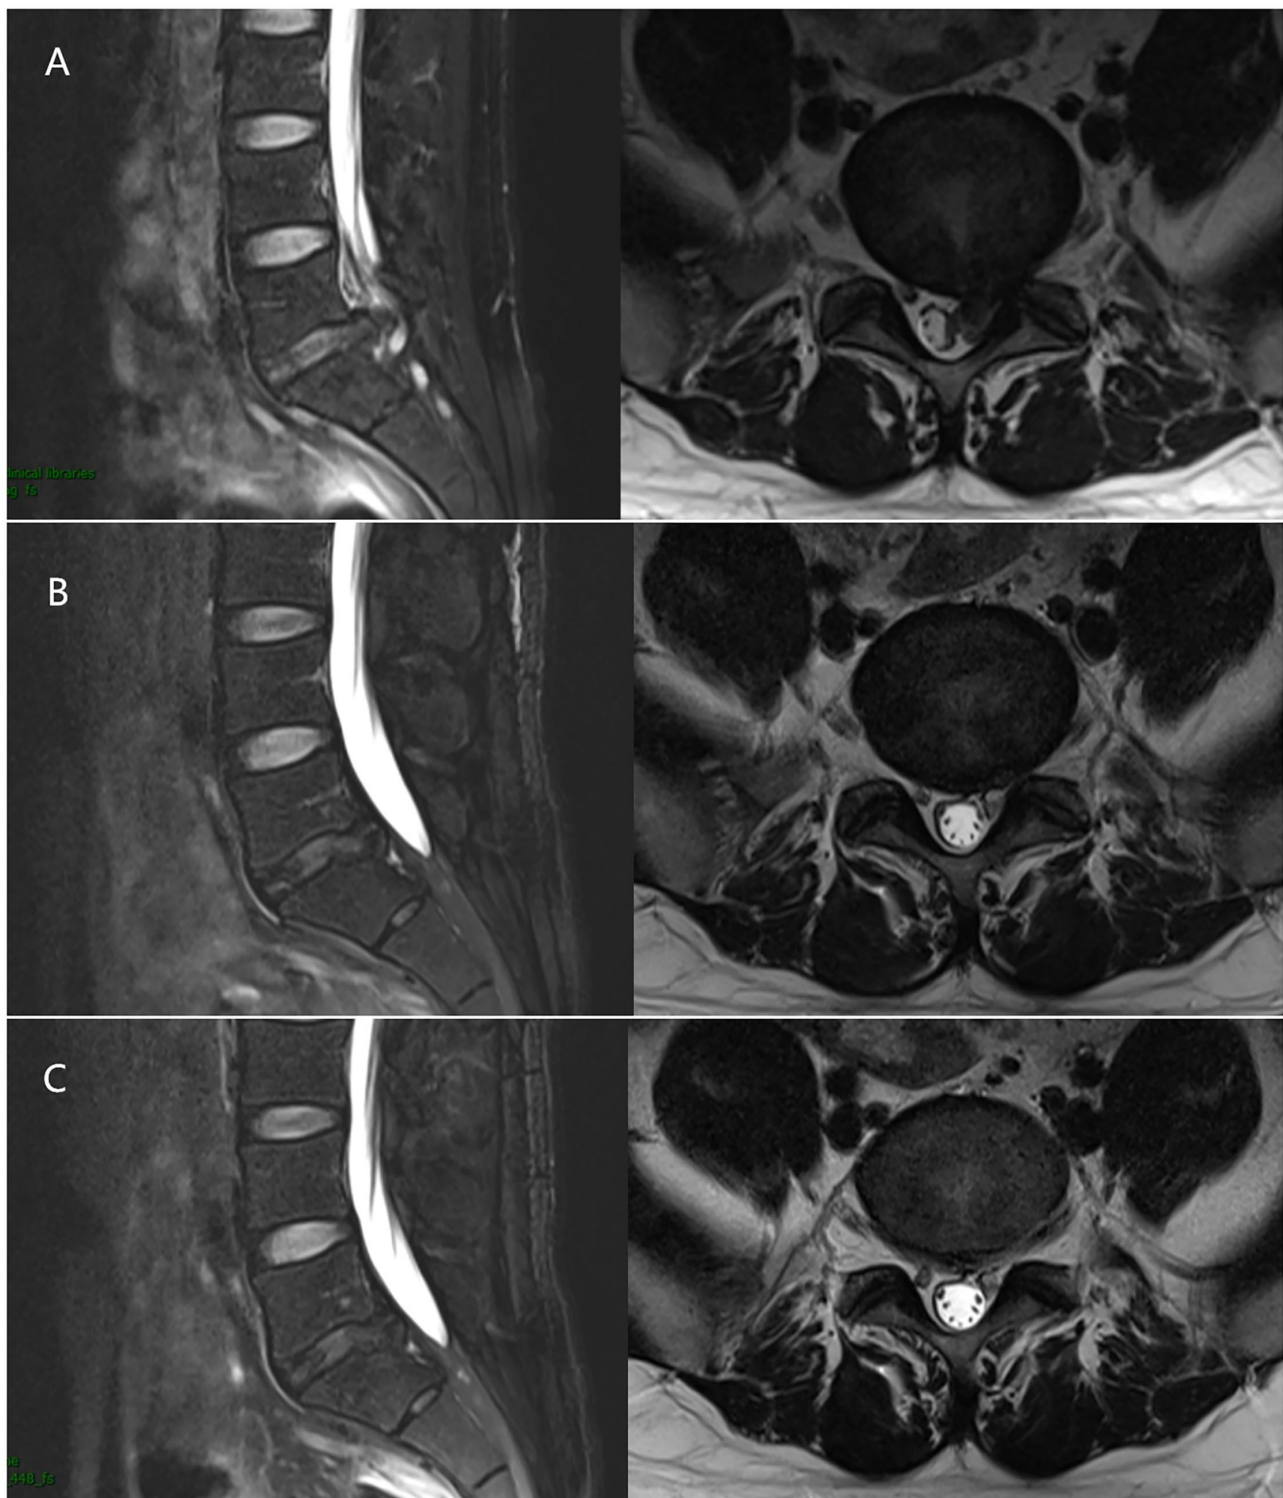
A 33-year-old male with the L5/S1 LDH underwent PELD. (A) Preoperative MRI showed LDH was located at the L5/S1 level. (B) 1 month after surgery, MRI revealed the nerve root was decompressed without recurrence. (C) 3 months after surgery, MRI revealed the nerve root was decompressed without recurrence as well.
